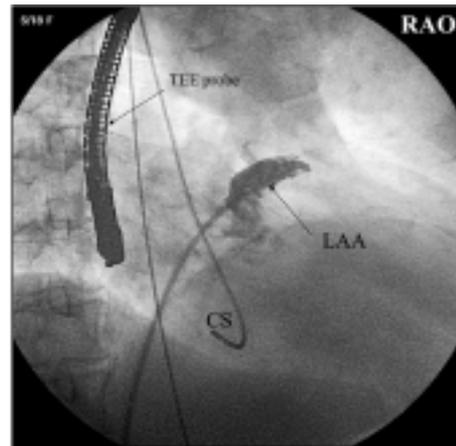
Fluoroscopic right anterior oblique (RAO) image of left atrial appendage (LAA) angiography. In order to choose the device size an average of three measurements (RAO and antero-posterior angiography and the best one by transesophageal echocardiography-TEE) should be obtained. CS = coronary sinus.
